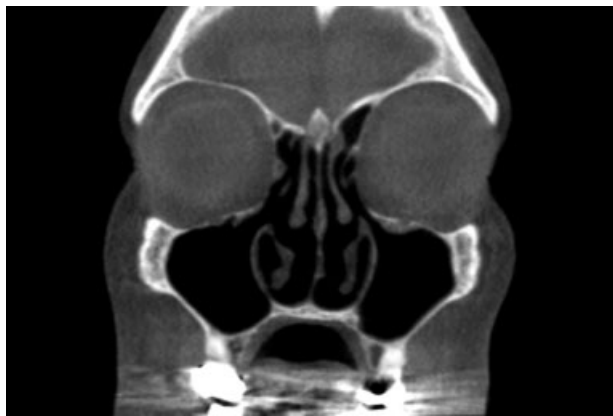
Sinus CT scan* following suctioning of both maxillary sinuses. Same appointment as ►Fig. 2. Sinus culture results showed normal flora. The patient was placed on twice daily off-label Budesonide/saline nasal irrigation therapy for 2 weeks with continued nasal saline irrigation twice daily thereafter. There was no recurrence of inspissated mucous at the 9-month follow-up appointment, with resolution of symptoms.
